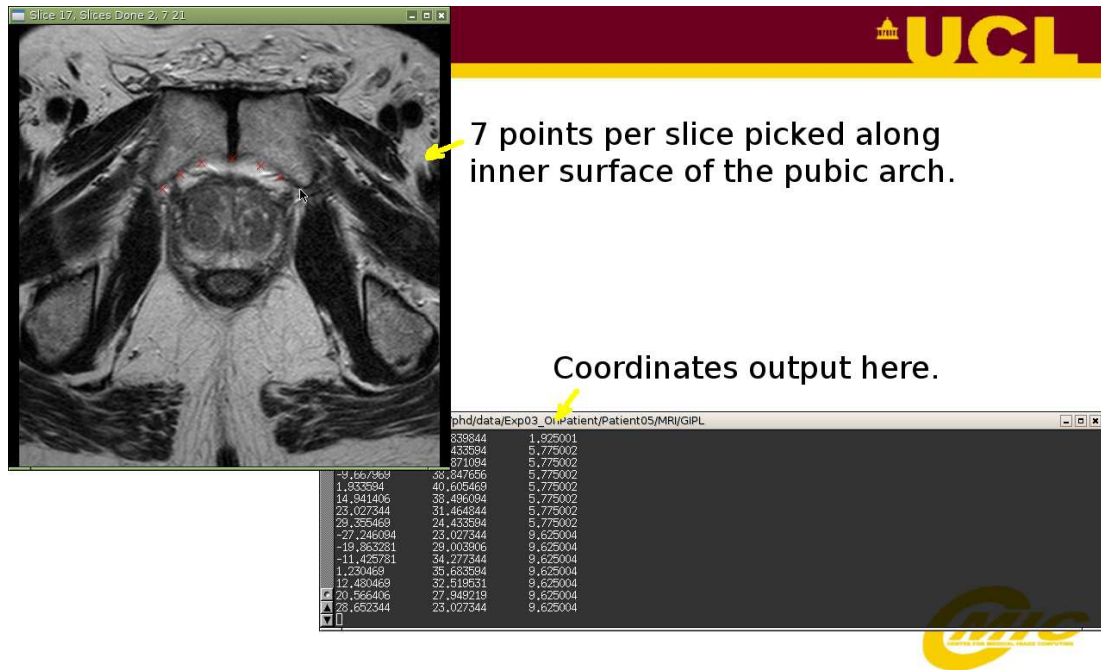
43 points on the inner surface of the pubic arch are manually picked from the preoperative MRI image. Using purpose built software this task can be completed in less than 5 minutes.
